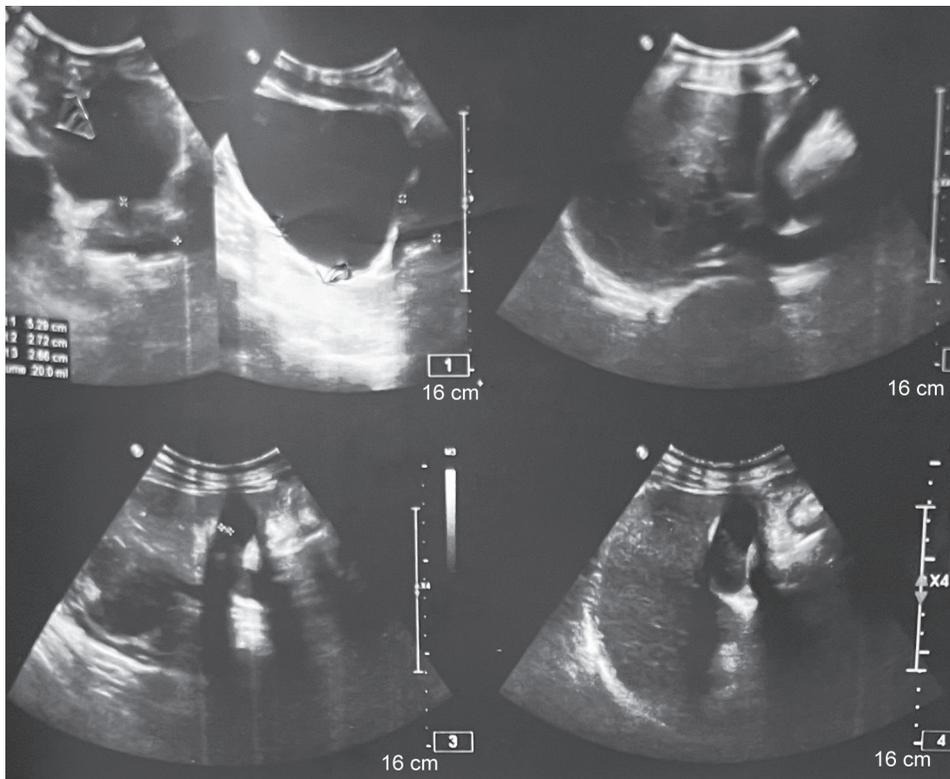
Ultrasonography abdomen suggestive of fluid collection of 214 cc noted tracking along the subdiaphragmatic region extending into the gallbladder fossa
